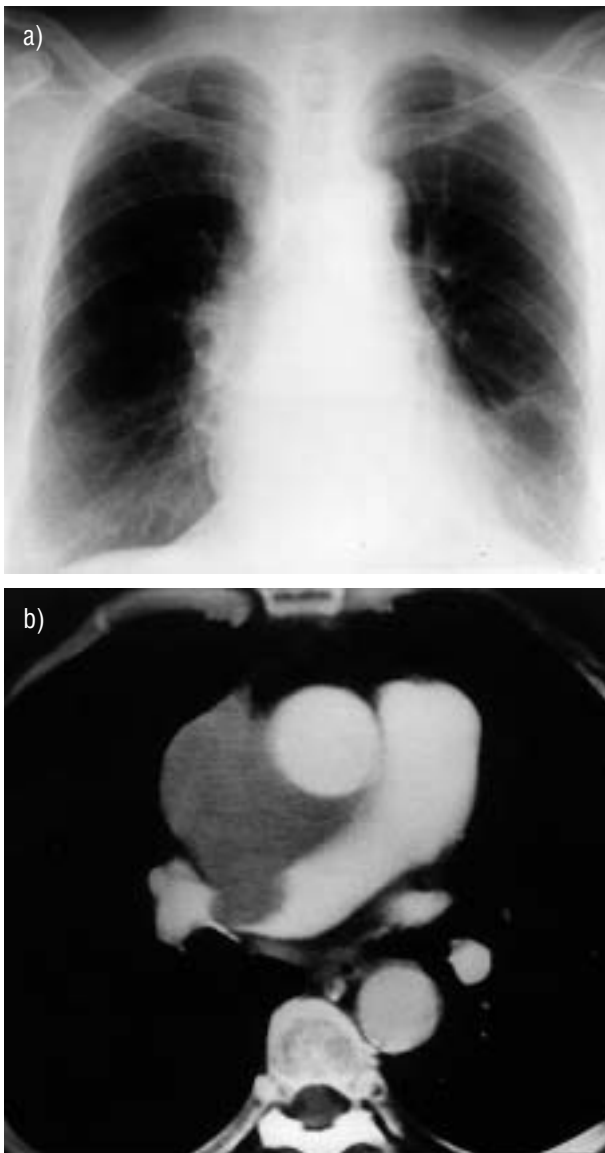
a) A 55-yr-old dyspnoeic female. Chest radiograph demonstrating widened mediastinum particularly on the right with reduced vascularity of the right lung. b) Contrast enhanced computed tomography showing central mediastinal mass invading the right pulmonary artery. Small cell carcinoma was confirmed on percutaneous biopsy.
